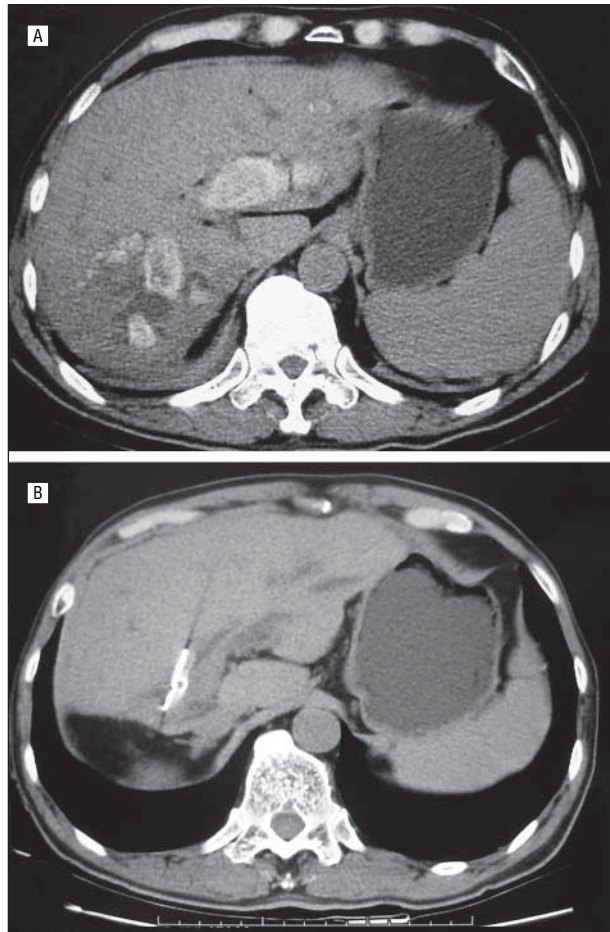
Computed tomography. The computed tomographic scans were taken before (A) and after (B) liver resection and postoperative cholecholesty.
